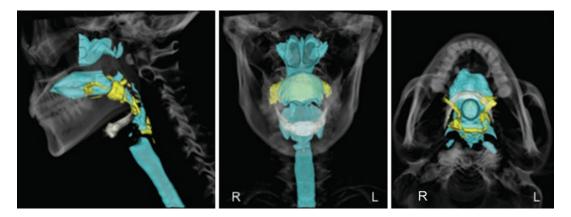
3D CT images. Healthy 34-year-old woman swallowing 10 mL of thin liquid. *Left*: lateral view, *Middle*: anterior view, *Right*: inferior view
